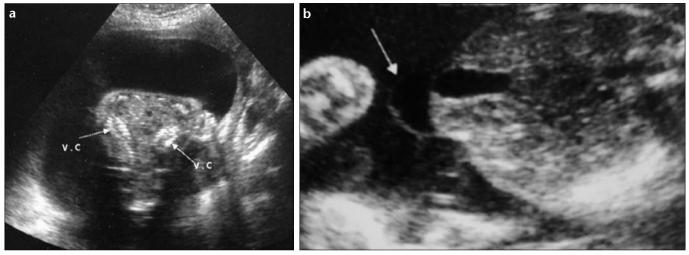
a, b. Fetal ultrasound examination at 24 weeks of gestation revealing two vertebral columns (V.C.) (a), and omphalocele (arrow) (b).
